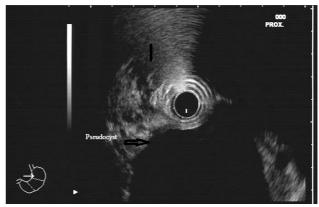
The endosonographic view of the patient with pancreatic pseudocyst as a result of thrombosis caused by polycythaemia vera
